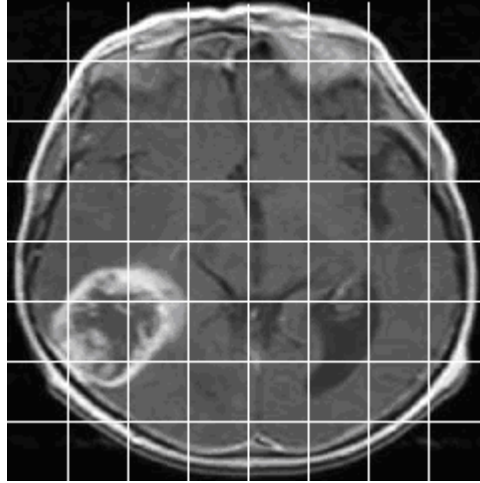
Subdivisions of MR image
